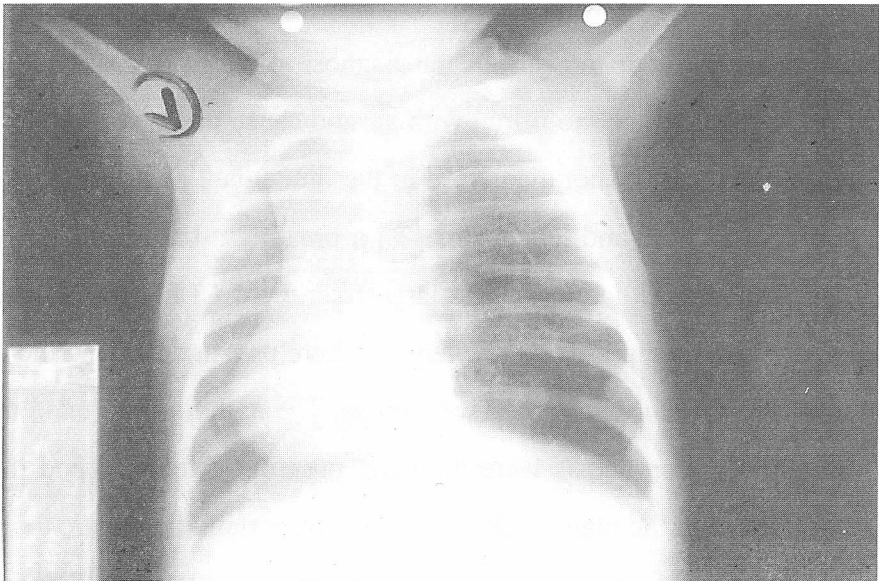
Typical chest X-Ray features of CLE
